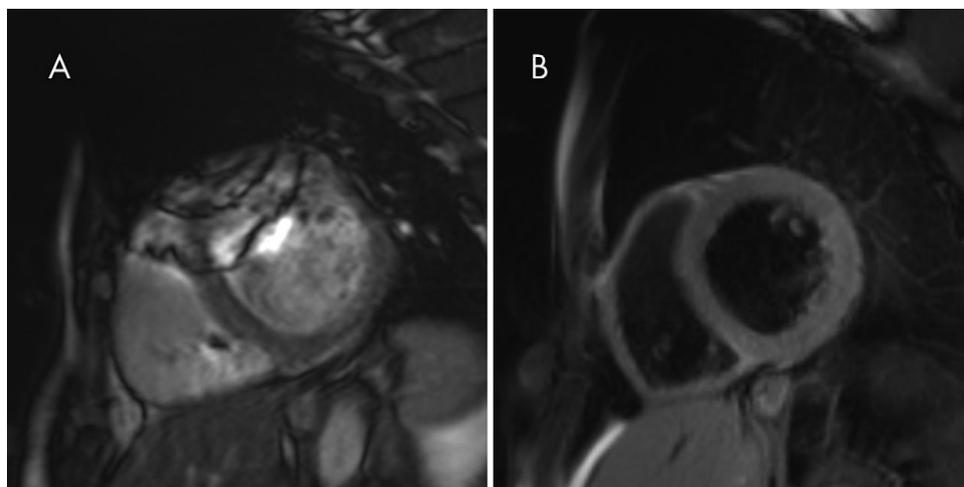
Images in a 61-year-old man with a Medtronic Evera MRI XT single-chamber implantable cardiac defibrillator imaged with a Siemens Magnetom Aera 1.5-T unit. Basal short-axis images acquired with, *A*, balanced steady-state free precession sequence and, *B*, spin-echo sequence (in this case T2 weighted), which is less sensitive to susceptibility artifacts.
